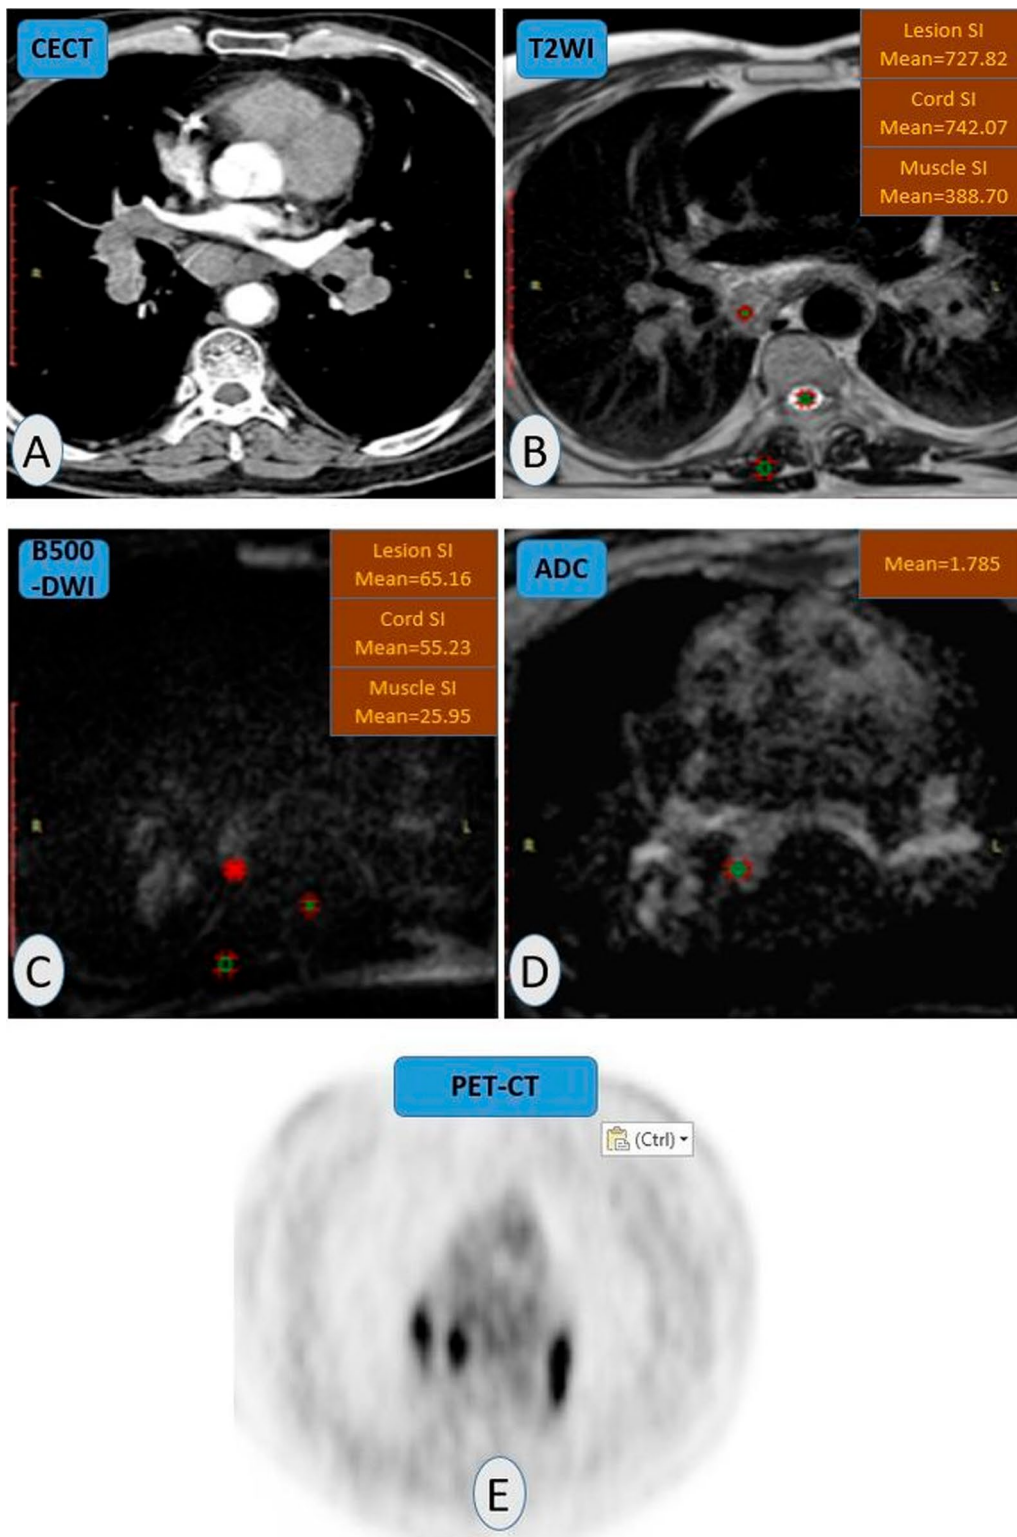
A 51 years-old-male patient complaining of dyspnea and cough. A Contrast-enhanced chest CT with multiple mediastinal and bilateral hilar lymph nodes. B T2WI-MRI showed a hyper-intense signal with lesion-to-cord signal ratio=0.96 and lesion-to-muscle signal ratio= 1.8. C b500-DWI showed a low signal with lesion-to-cord signal ratio = 1.18 and relative contrast ratio = 2.5. D Mean ADC value = $1.7 \times 10^{-3} \text{ mm}^2/\text{s}$ (no restriction). E PET-CT examination showed high FDG uptake (false positive hot spot) ... Pathologic proven sarcoidosis
